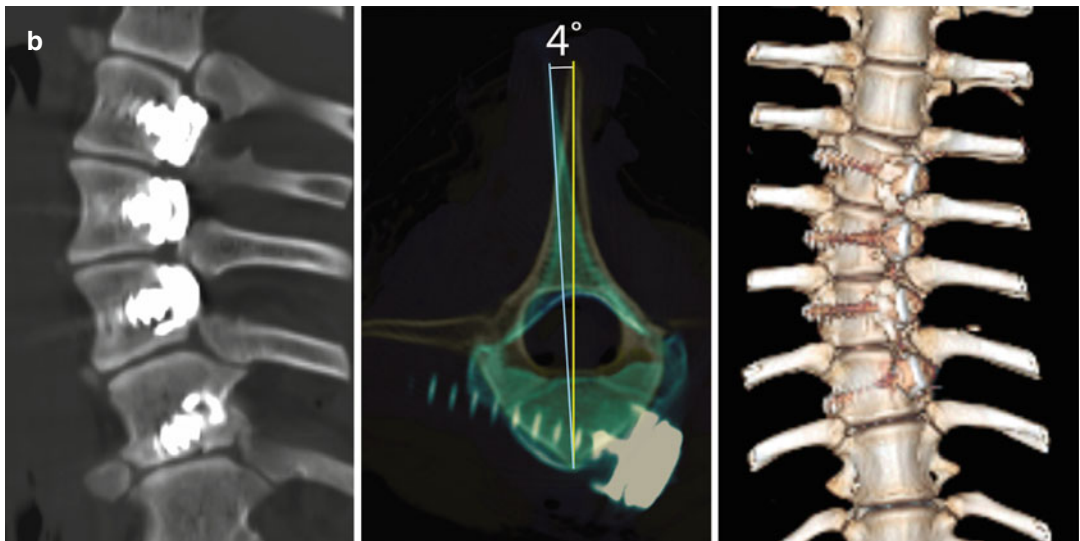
(a) Radiographs showing creation of spinal curvature with a tether (radiolucent) in six months of treatment. (b) Representative computed tomography (CT) imaging done after 12 months of spinal growth modulation
